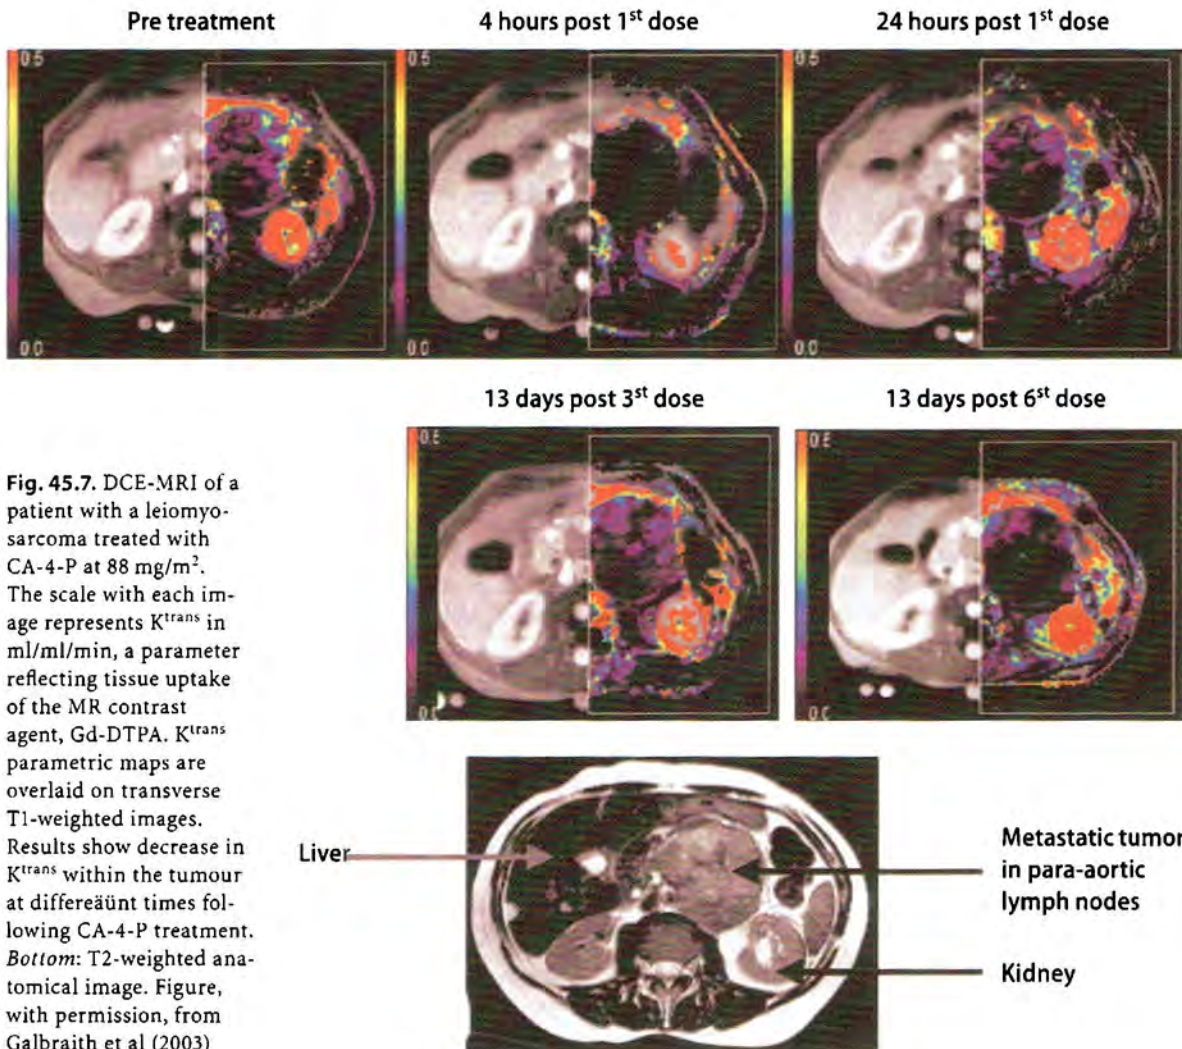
DCE-MRI of a patient with a leiomyosarcoma treated with CA-4-P at 88 mg/m². The scale with each image represents K^{trans} in ml/ml/min, a parameter reflecting tissue uptake of the MR contrast agent, Gd-DTPA. K^{trans} parametric maps are overlaid on transverse T1-weighted images. Results show decrease in K^{trans} within the tumour at different times following CA-4-P treatment. *Bottom:* T2-weighted anatomical image. Figure, with permission, from Galbraith et al (2003)
